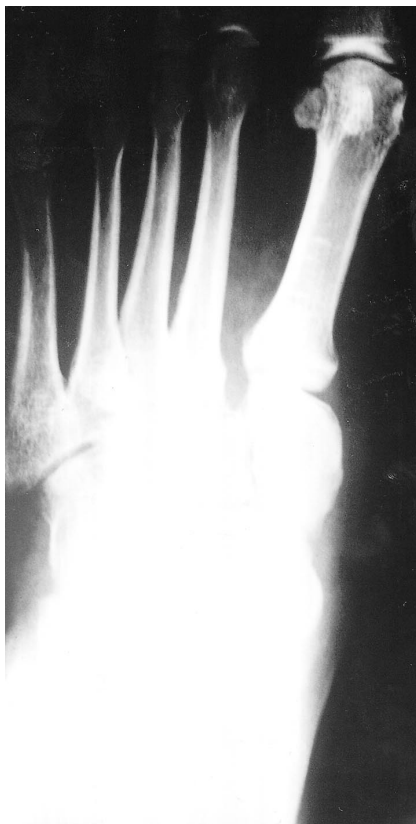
Plain radiographs show healing of stress fractures of the 3rd and 4th metatarsal necks. The 4th metatarsal fracture is impacted.
